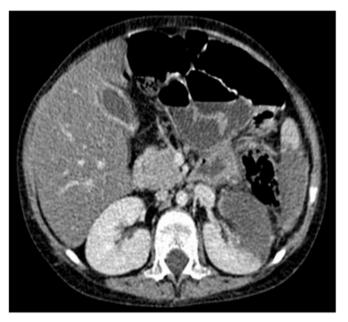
CT scan showed colonic mural thickening in the splenic flexure, infarct formation in the kidney and spleen which were suggestive of IA on the 8th day.
